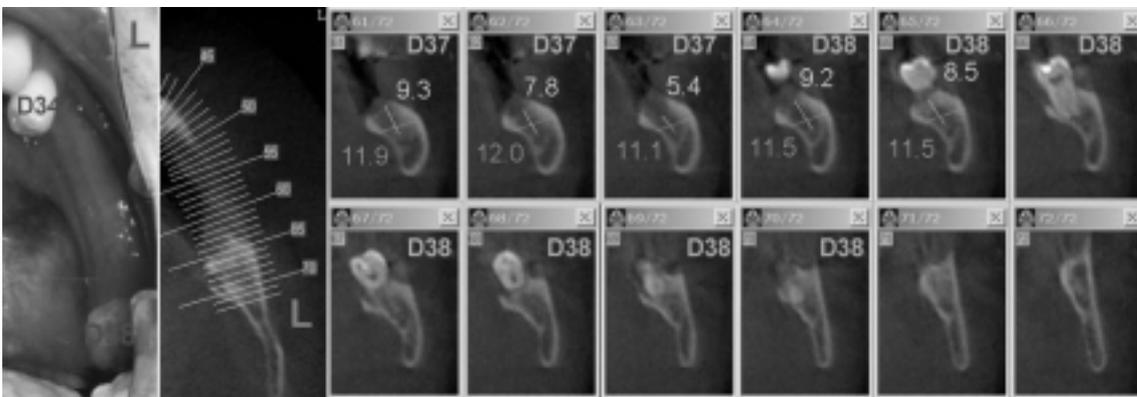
Before surgery 3D CT reconstruction
